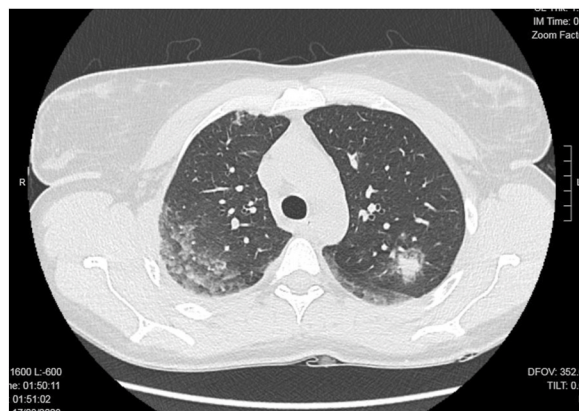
High-resolution computed tomography scan of the chest shows multiple areas of parenchymal hyperdensity with a nodular appearance and diffuse ground-glass opacities.
